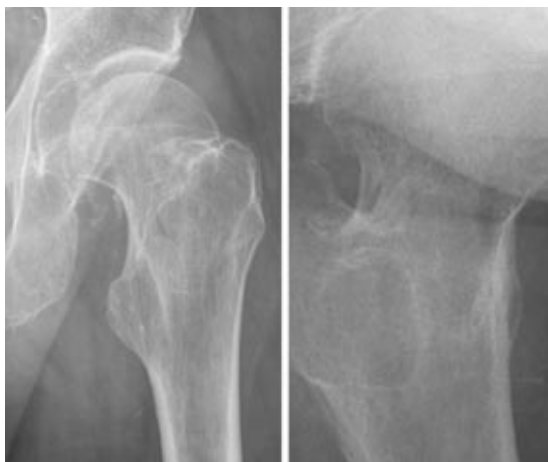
Anteroposterior (left) and lateral (right) radiographs of the left hip; no fracture is visible
